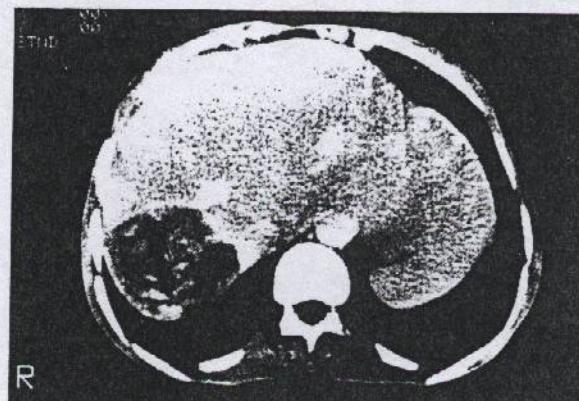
CT scan showing the typical appearance of hydatid cyst in the right lobe of the liver.*
